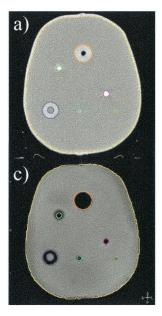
Examples of planar coregistration images showing offset (left) and aligned (right) image data sets. (a) Grayscale sagittal primary CT image with colorwash of second CT scan overlaid. (b) Coronal primary CT image with the second CT scan overlaid. (c–e) Grayscale axial primary CT image with overlaid colorwash of second CT scan, MRI scan, and PET scan, respectively.
